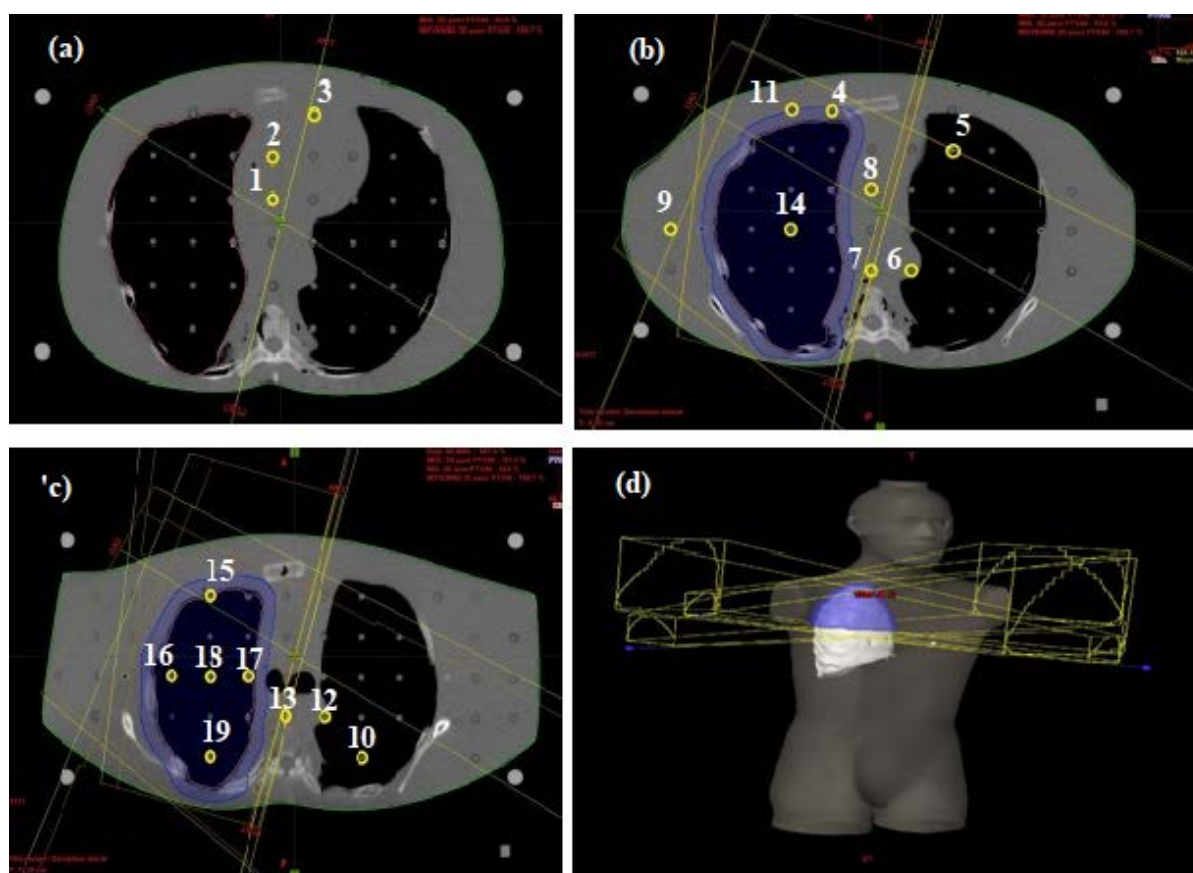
TLD positions shown on CT-slices with radiotherapy beams angles for 3D-CRT: (a) slice with $y=6.3\text{cm}$, (b) slice with $y=9\text{cm}$, (c) slice with $y=12.3\text{ cm}$, (d) 3D fields viewing with PTV (in blue).
